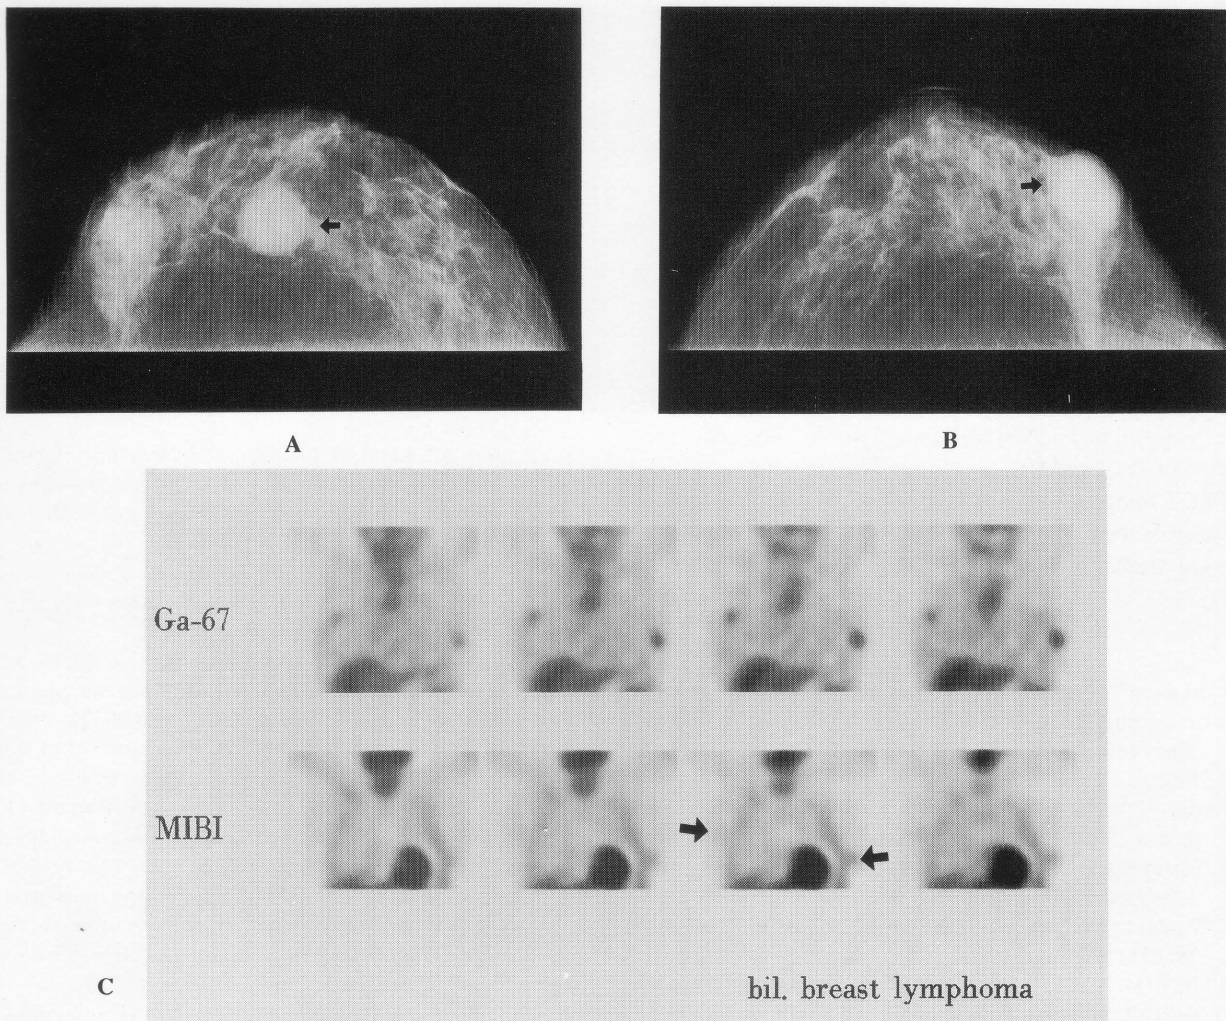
A) A 57 year old woman with NHL of both breasts. Craniocaudal mammogram of the right breast demonstrates well-defined mass (\uparrow). (March, 1994); B) Craniocaudal mammogram of the left breast demonstrates well-defined mass as well as right breast mass (\uparrow). (March, 1994); C) SPECT of Ga-67 (upper) shows markedly increased uptake in both breasts. SPECT of Tc-99m MIBI (lower) image shows a minimal increased accumulation in the both breast (\uparrow). And in the right breast, the location of the tumor is complicated by the high levels of activity present in the chest wall. (March, 1994)
